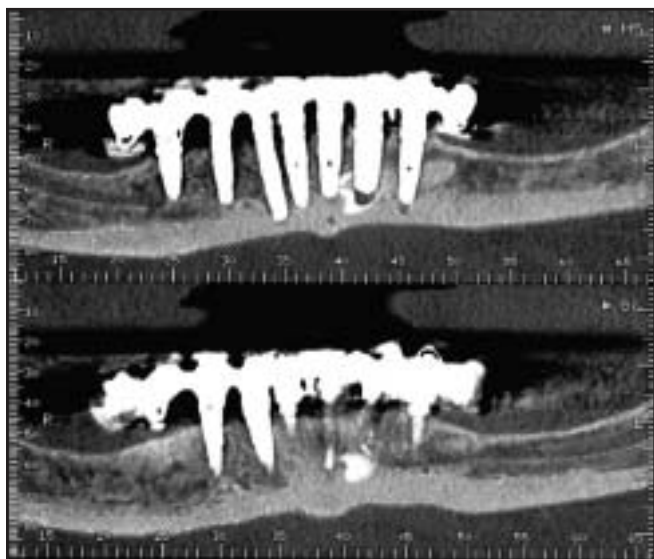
Panoramic section of the CT scan at the 2-year recall. The section confirms that one implant's apex is in contact with bone, while the other is not. No abnormal bone reaction or root resorption could be detected.
